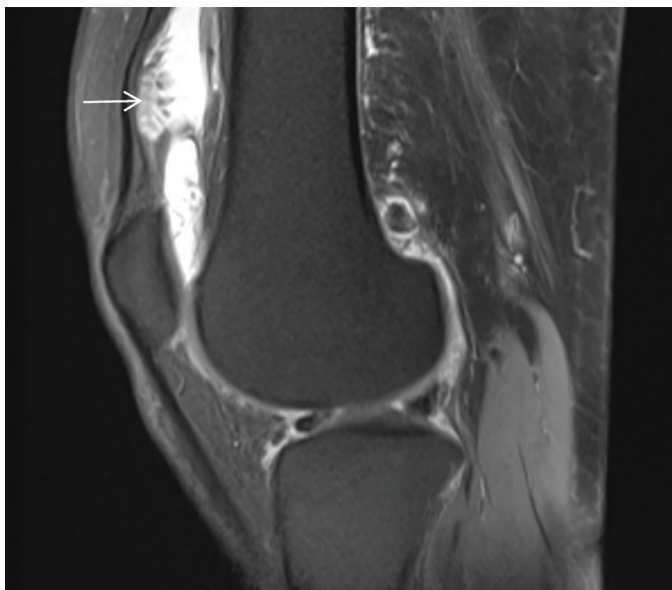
Magnetic resonance imaging of knee and lipoma arborescens (white arrow)
